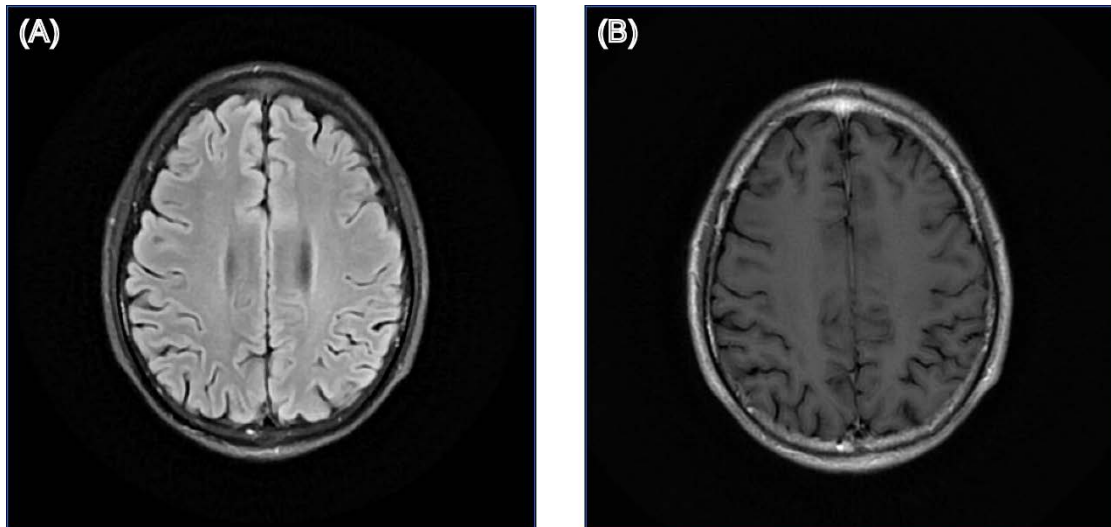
Structural brain MRI images of patient 23. (A) T2-weighted fluid-attenuated inversion recovery (T2-FLAIR) image; (B) Gadolinium-enhanced T1-weighted (Gd-T1w) image.
